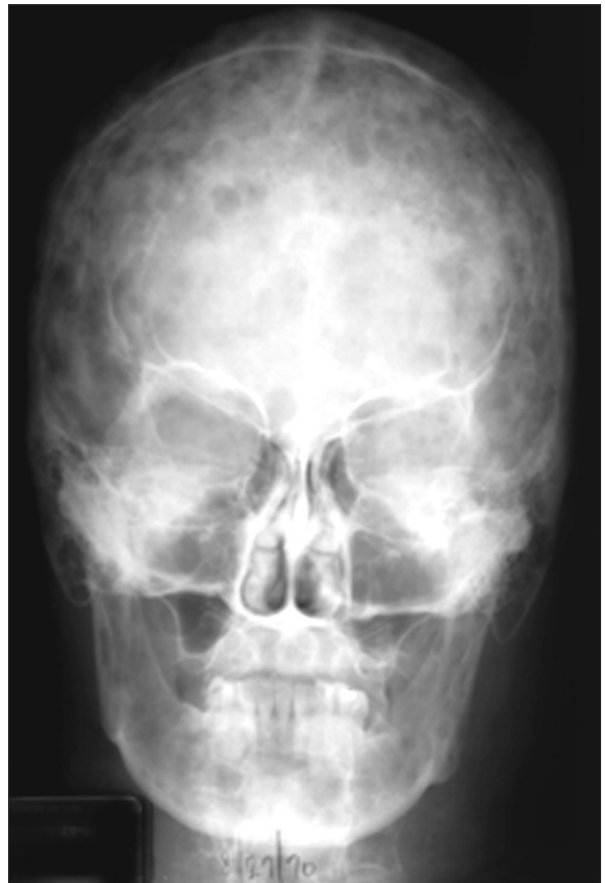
This anteroposterior skull radiograph cross-references Figure 1 to display the multiple lytic defects throughout the skull and mandible.
